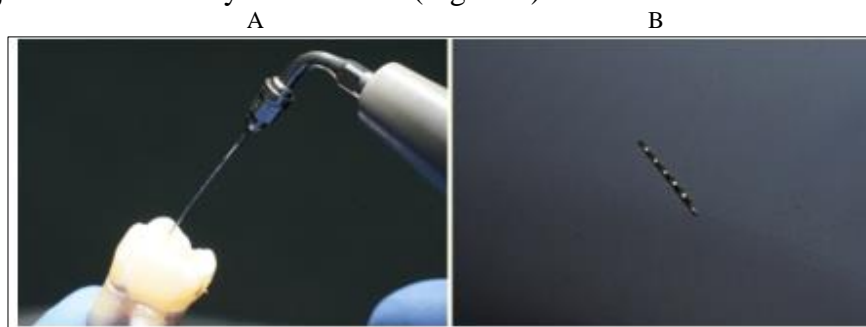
A). Attempting to remove the separated fragment with ultrasonic tips; B) Fragment retrieved
